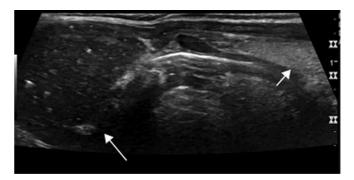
Ultrasound image of a thyroglossal duct cystic mass (long arrow), located superior to the thyroid gland (small arrow). Typically, these are midline, complex cystic masses with internal debris and a pseudosolid appearance. They are well-circumscribed, with through transmission and edge artifact. From Figure 130.4, Case 130 of Scoutt LM, Hamper UM, Angtuaco L, eds. *Ultrasound*. Oxford, UK: Oxford University Press; 2017.
